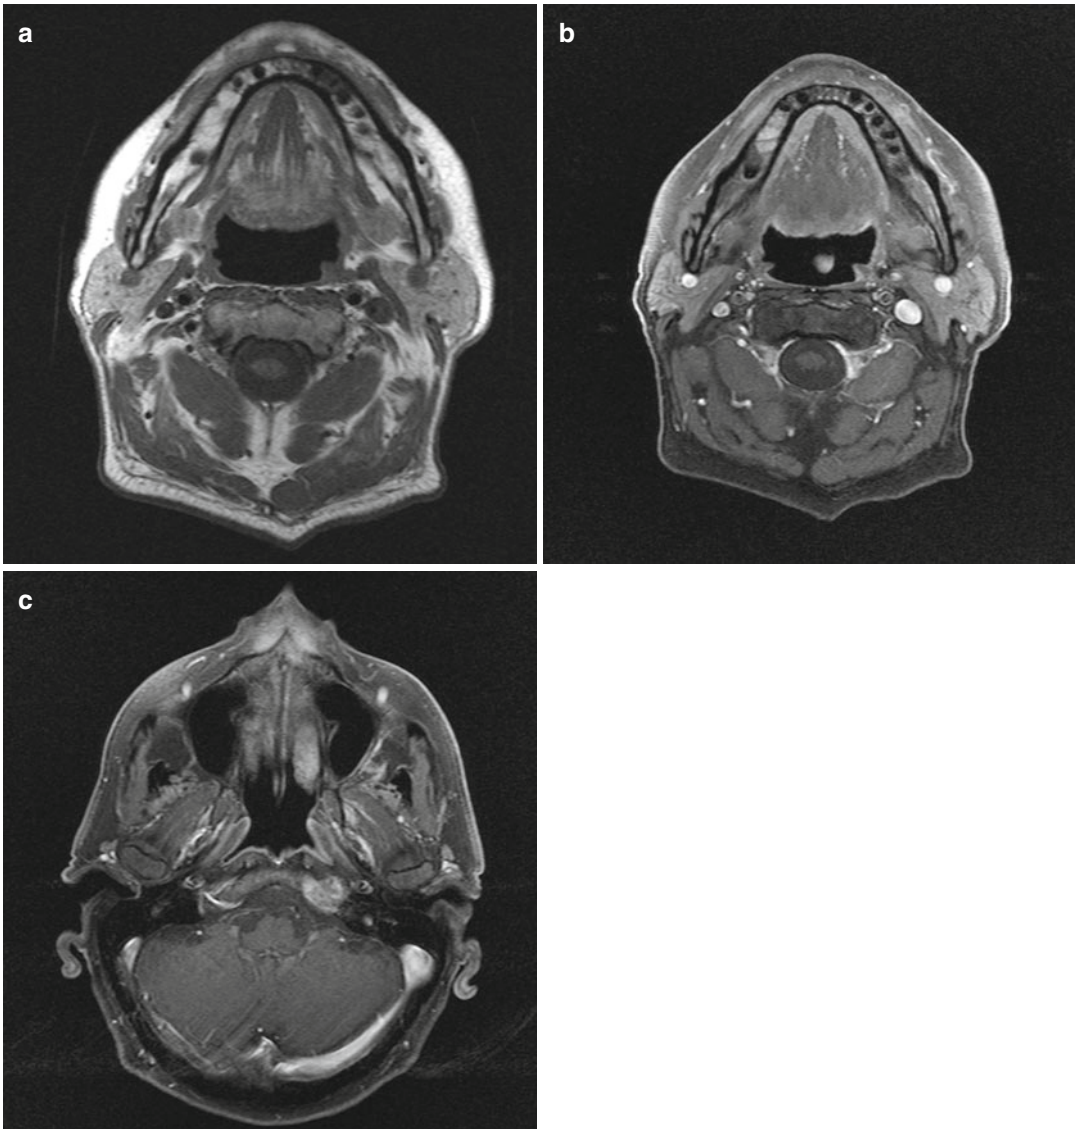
(a–c) A 61-year-old woman with breast cancer and symptomatic osteonecrosis. Axial T1-weighted image (a) shows focal lesion of osteonecrosis in the left mandible as hypointense zone without cortical affection. After
